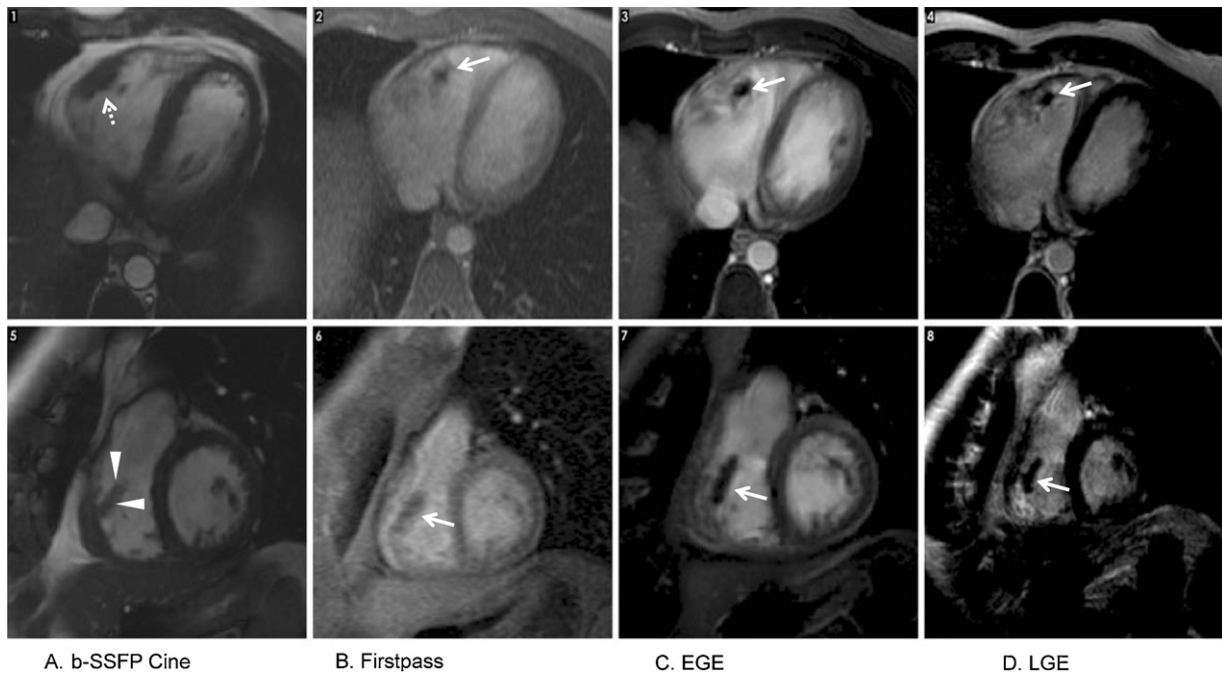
Cardiovascular magnetic resonance imaging. Top row axial cut. Bottom row sagittal cut. A mass (white dash arrow) is seen invading the right ventricle free wall (1 and 5) with a very mobile pedicle extension (white arrowheads). Heterogeneous signal is seen after gadolinium administration except for the pedicle structure (white arrows) suggesting the presence of thrombus or necrotic tissue (2, 3, 4, 6, 7 and 8). EGE, early gadolinium enhancement. LGE, late gadolinium enhancement.
